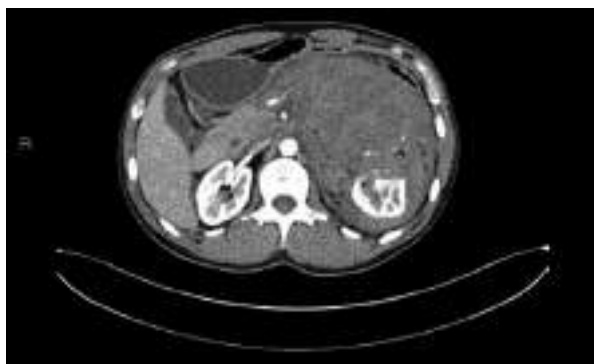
Abdominal CT – adipose tissue in the tumor indicates an angiomyolipoma
